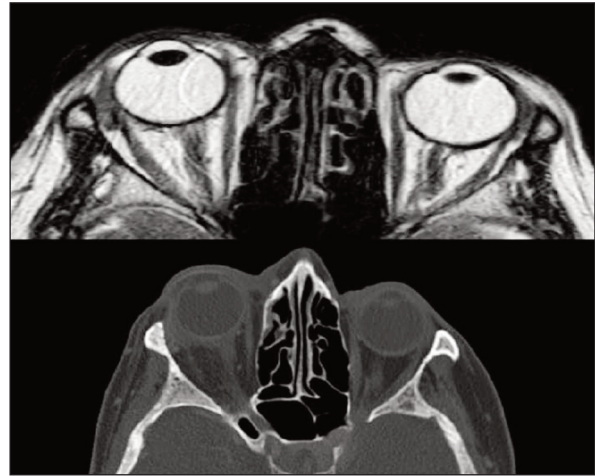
Magnetic resonance imaging and computed tomography sequences of the patient reported as clean.
